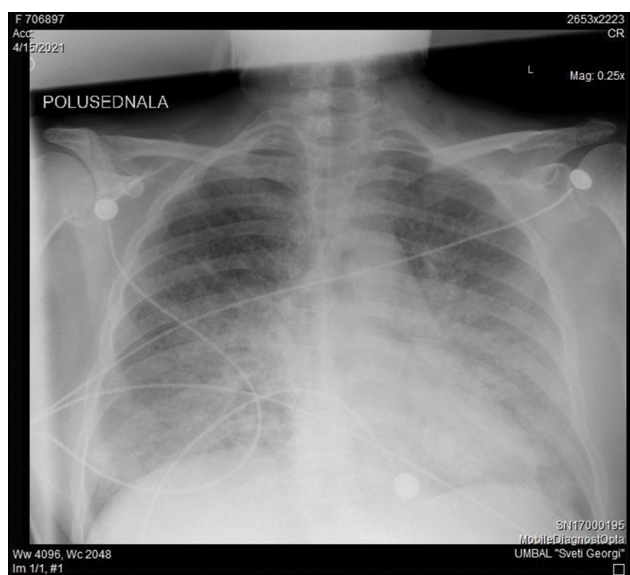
Repeat chest-X-ray, day 23, bilateral intestinal opacities with peripheral distribution in the lower fields.
